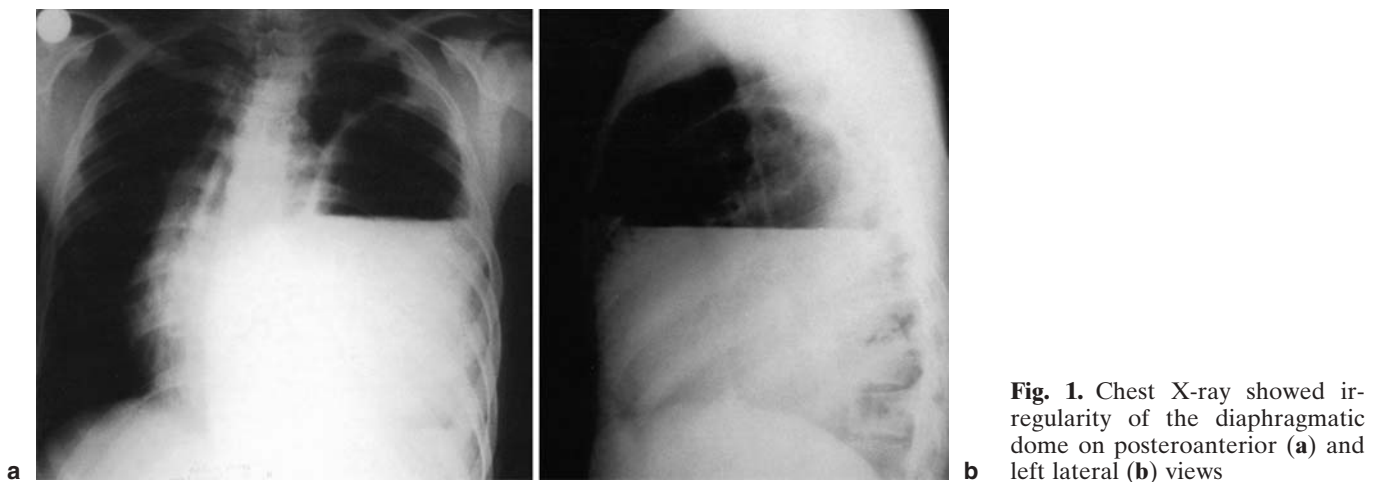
Chest X-ray showed irregularity of the diaphragmatic dome on posteroanterior (a) and left lateral (b) views
